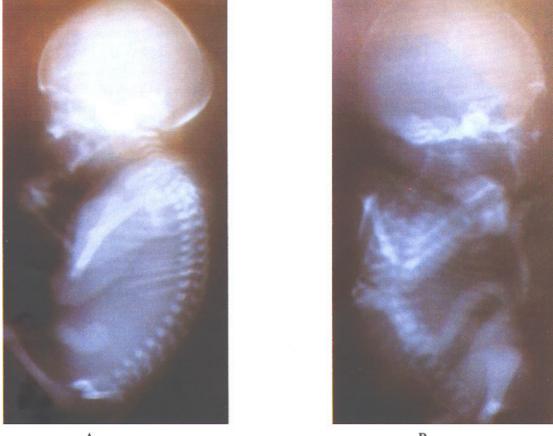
2B. Radiographs of the same infant, with subtotal sacral agenesis and one femur. Lateral and oblique views
